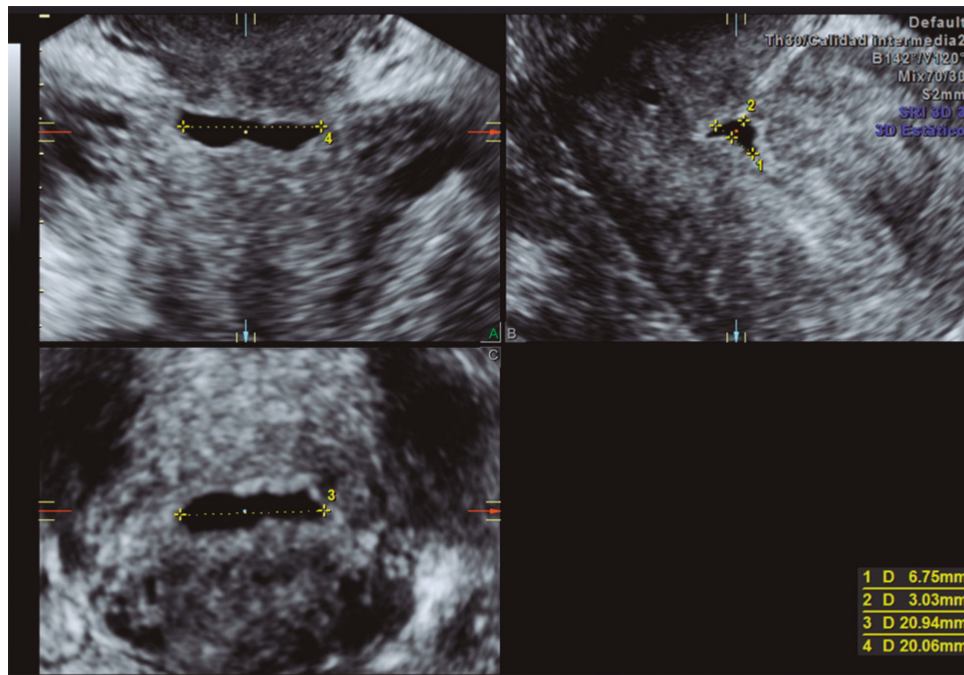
Three-dimensional transvaginal ultrasound image of isthmocele.
